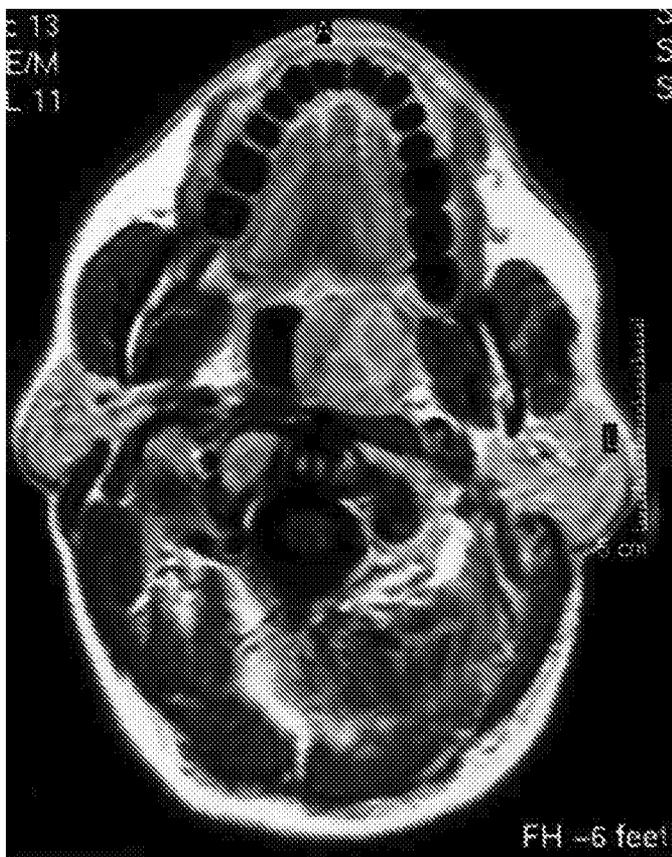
Axial section T1-weighted MRI scan revealing a large mass occupying the post-nasal space.
